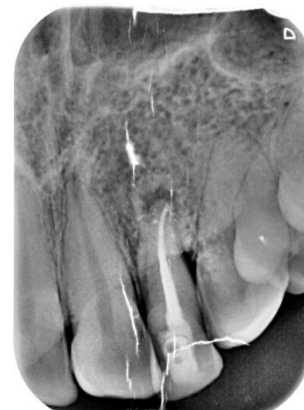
the six-month radiograph recall, showing progressive healing of the bone around the root.
